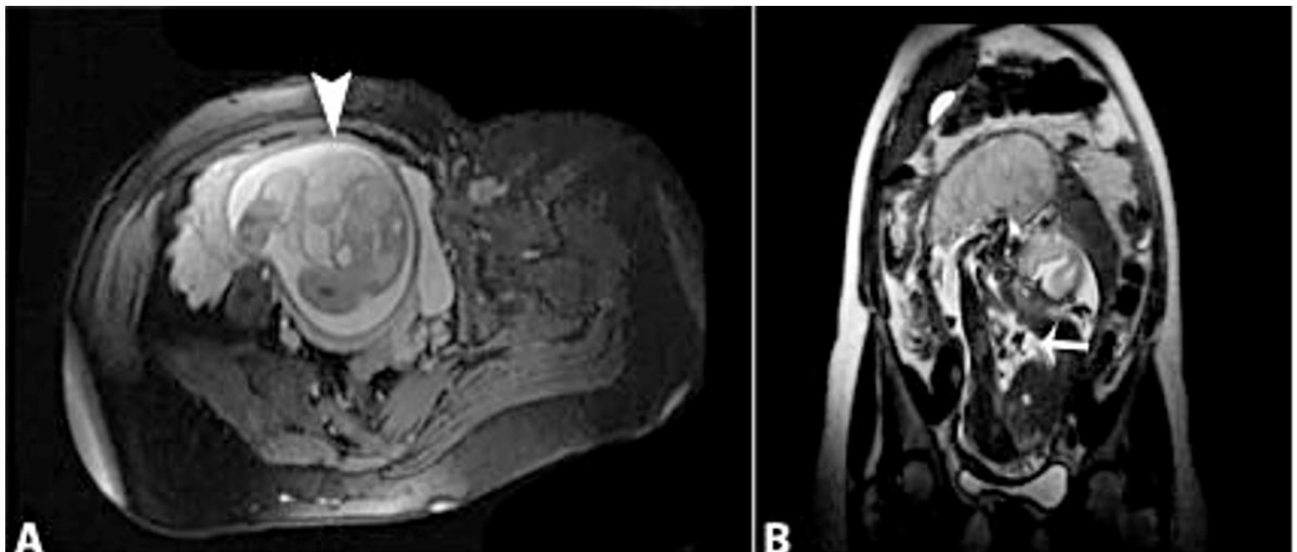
T2-weighted fetal MRI at 24 weeks' gestation. a - Axial view showing subcutaneous lymph collection (arrow); b - Coronal view showing lymphatic malformation extending to the knee (arrow).
